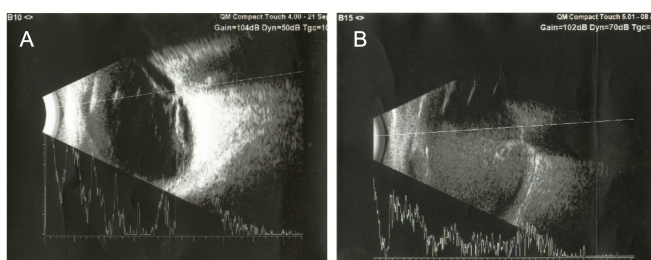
Ultrasound images of the left eye of the patient. A: Before the cataract surgery (2017). Note the proliferative membranes under the cataract. B: Nine months after the surgery (2018): emulsified silicon oil and the recently formed proliferated membrane was detected.
